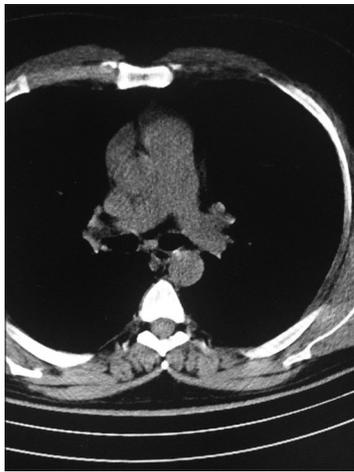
Computed tomography of the patient demonstrating no pulmonary embolism during admission for COVID-19
